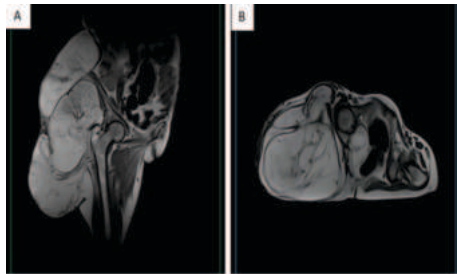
MRI Showing Right Gluteal Tumor Lobulated Invading Gluteal Muscles Without Involving Skin (A) Sagittal Section (PD TSE) (B) Axial Section (T1W)
